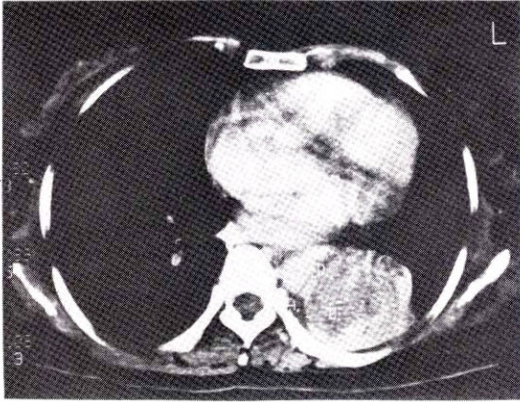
Computed tomogram of the chest showing left lower lobe collapse and aortic invasion from the tumor
